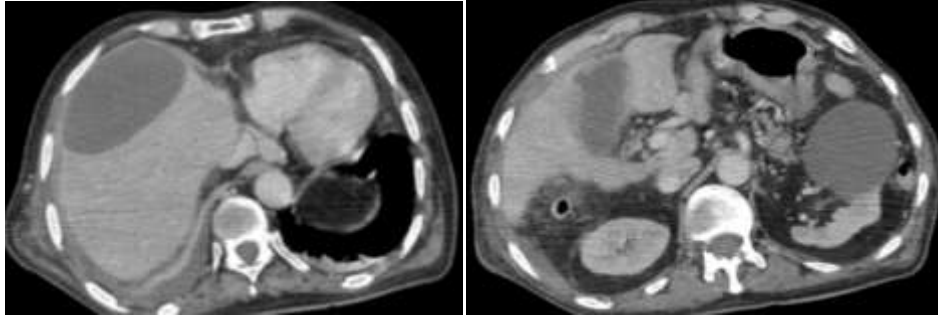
Computed tomography scan with intravenous contrast in the axial plane showing (A) hypodense subcapsular and (B) a thickened gallbladder wall with the entrance of the fistula feeding off the biloma (yellow arrow).
